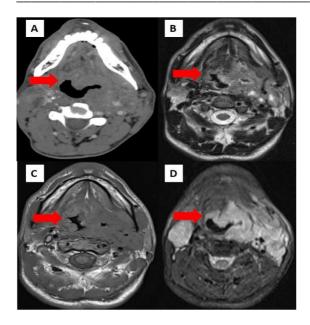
IMAGING FINDINGS: Well-defined soft tissue density lesion with heterogeneous enhancement on CECT (2A), hyperintense on T2WI (2B), STIR (2D) and hypointense on T1WI (2C). The lesion is centred on left base of tongue, crossing midline (which is not depicted on CECT but is clearly depicted on corresponding MRI image) with inferior extension to involve median and left lateral glosso-epiglottic folds, left vallecula, lateral extension to involve left lateral pharyngeal wall and involvement of left parapharyngeal space
